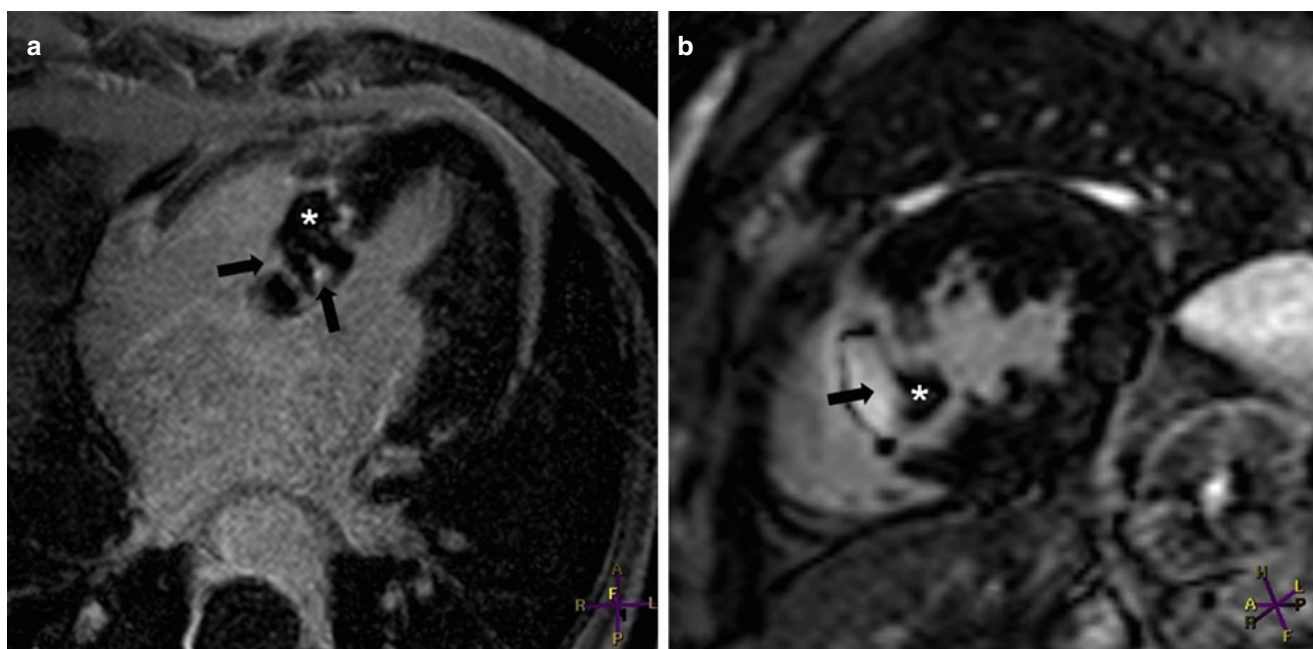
Images from a 53-year-old woman who had symptomatic asymmetric hypertrophic cardiomyopathy. Two days after alcohol septal ablation, delayed enhancement (DE)-magnetic resonance imaging was performed in (a) the four-chamber orientation and (b) the mid-left
